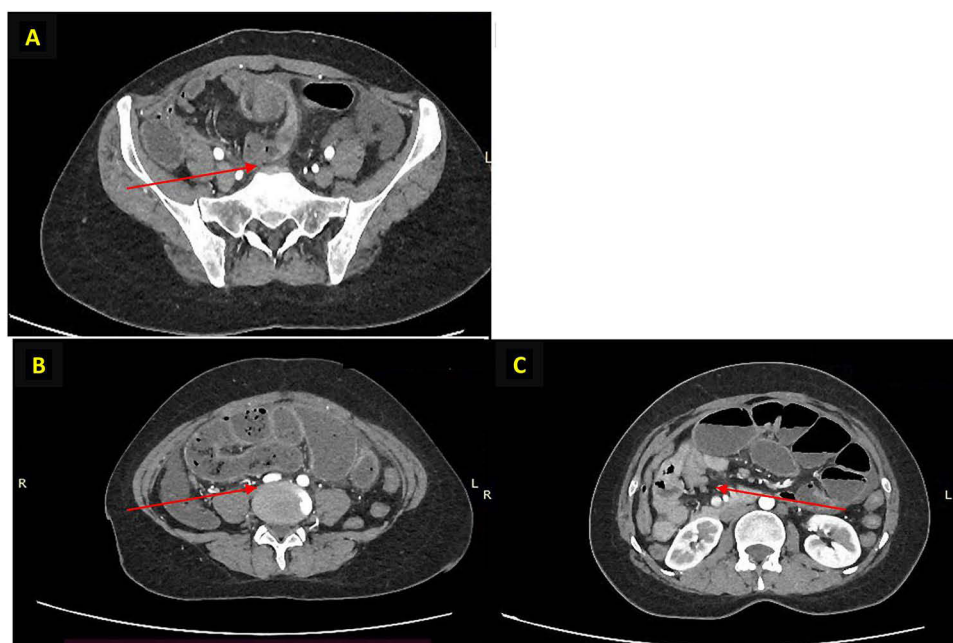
Contrast-enhanced computed tomography (CT) of the abdomen and pelvis showing long-segment bowel wall narrowing involving the terminal ileum and caecum (arrows), with upstream small-bowel dilatation up to 4 cm and multiple air–fluid levels. (A) Axial pelvic view. (B) Axial mid-abdominal view. (C) Axial upper-abdominal view.
